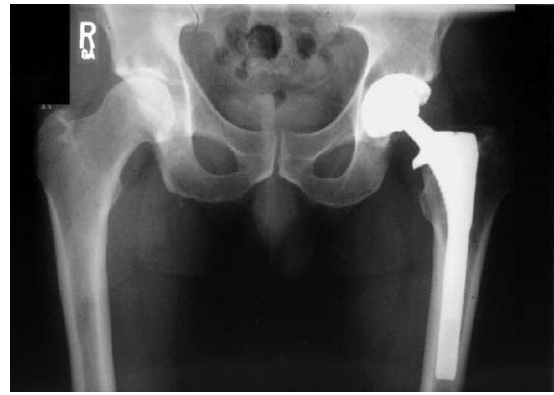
Case 2. Six months–postrevision radiograph of left hip demonstrating 32-mm zirconium ceramic head mated with polyethylene acetabular insert. Intraoperatively, at the time of revision, both the femoral and acetabular components were tested and found to be well fixed. There are no radiolucencies or osteolysis in either the pelvis or acetabulum.
